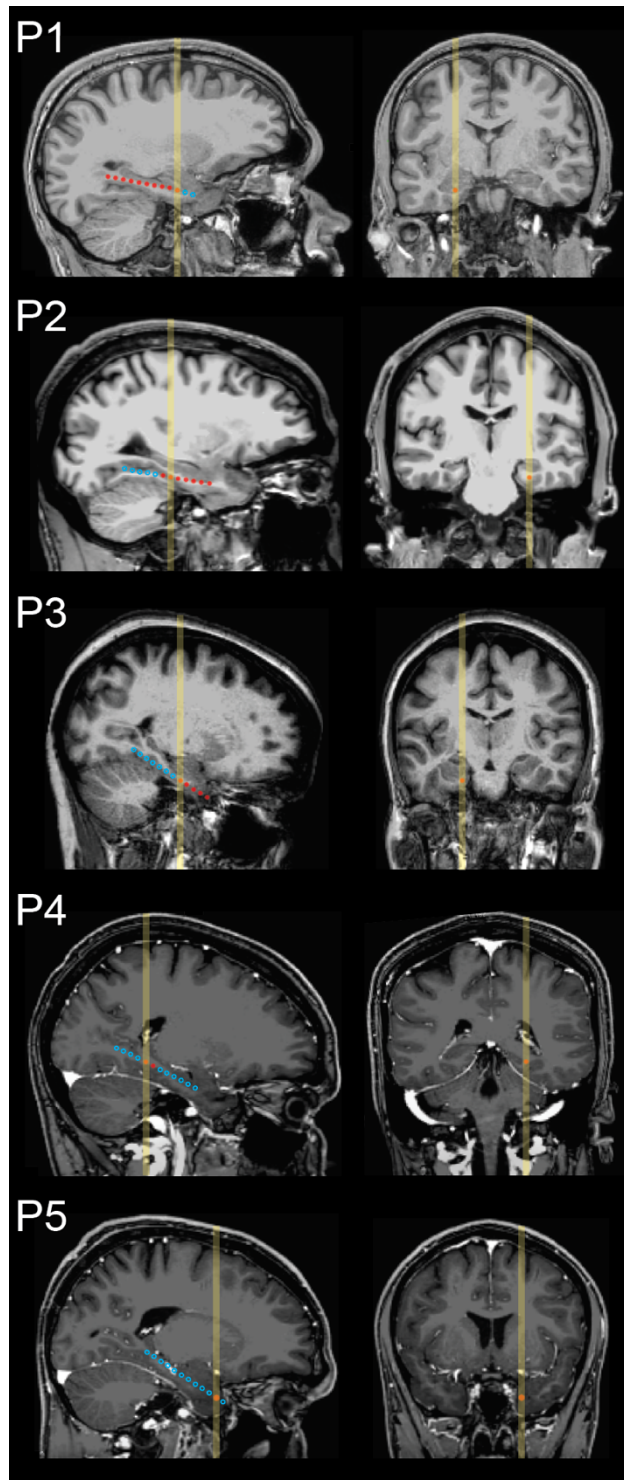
Locations of intracranial electrodes used to monitor medial temporal activity in patients P1-P5. Depth probes were implanted through a small hole in the skull and targeted for the hippocampus, guided by anatomical information from pre-surgical MRI. Contacts were cylindrical, 1.25 mm in diameter and 2.5 mm long, situated 5 mm apart along each probe (measured center-to-center). Images on the left show a sagittal section that includes the estimated location of the contact selected for primary iEEG analysis as an orange circle. Locations of other contacts within the section are shown as red circles. Locations of contacts in adjacent sagittal sections were projected onto approximate locations in the section and shown as open blue circles. The yellow vertical line on each sagittal and coronal image indicates the location of the selected contact and corresponds to the approximate level of the section opposite.
